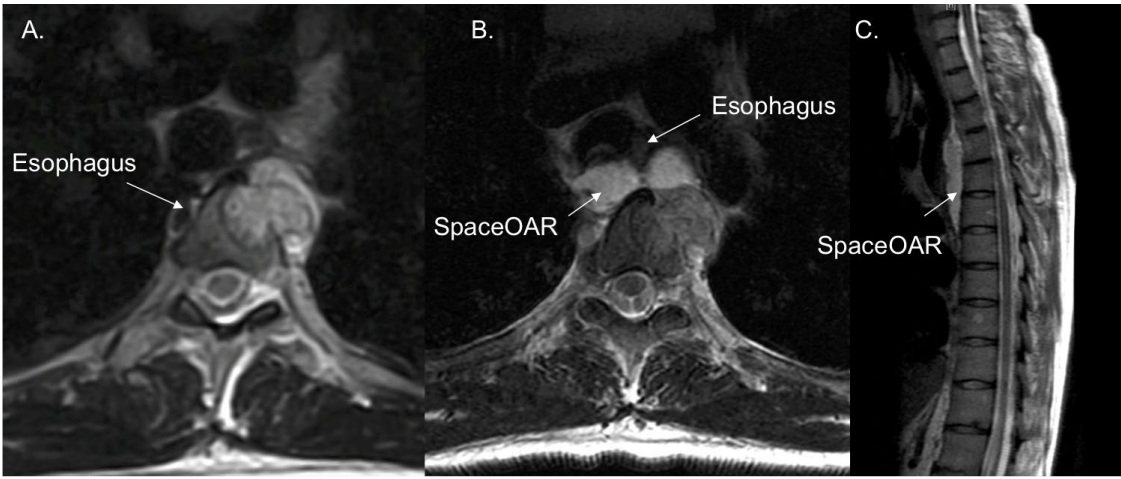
Representative T2-weighted MRI views, acquired at diagnosis (A), and following spacer insertion axial (B) and sagittal (C).
